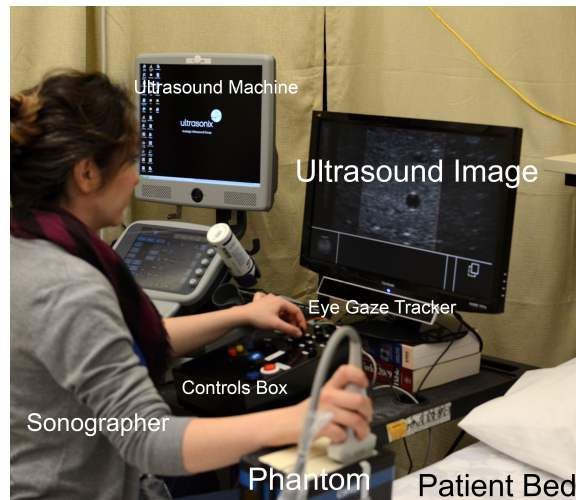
The Clinical User Study Room Setup: the setup in the lab closely matches the setup of an ultrasound room in a hospital.
